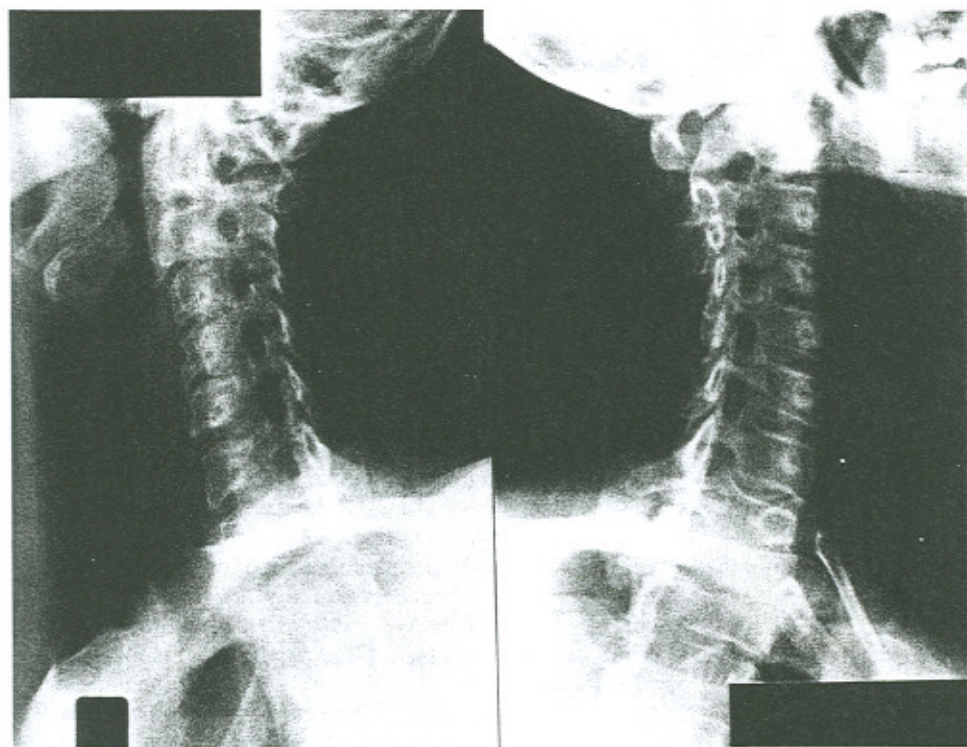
Oblique radiographs of the cervical spine of the 45-year-old female presented in Case 2. No abnormality can be seen on these films.
